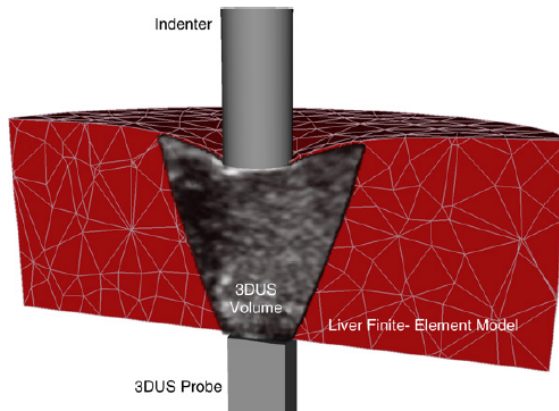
FE liver model, experimentally measured boundary conditions and co-registered 3D ultrasound sequence from [Jordan et al., 2009].*
